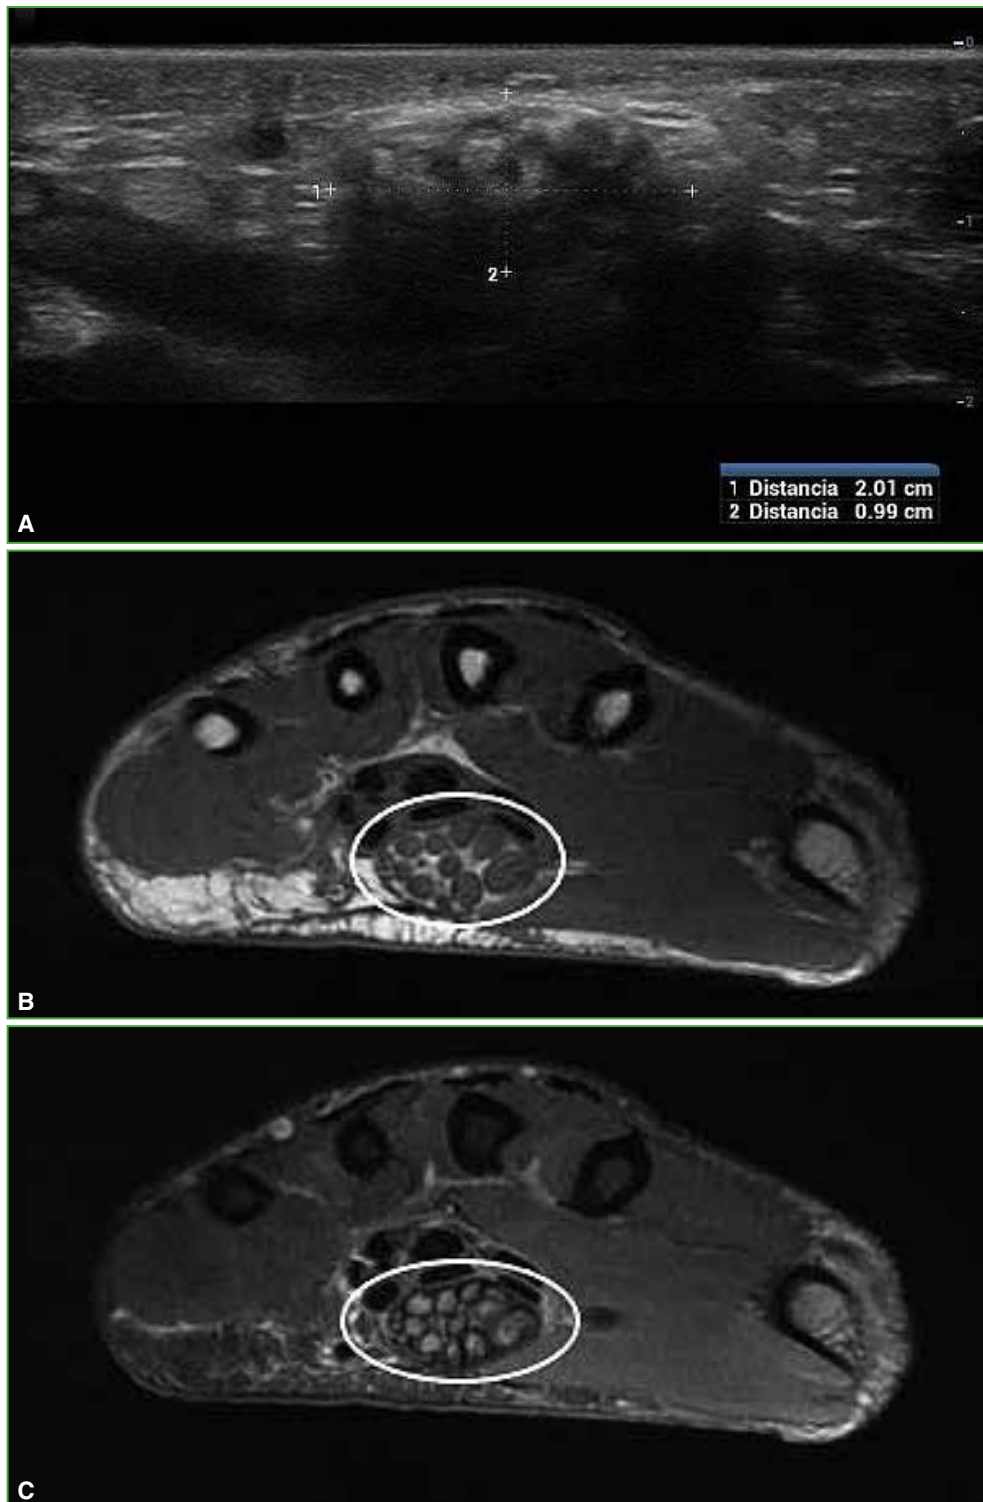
A. Ultrasound of the right wrist with a heterogeneous tumor in the carpal canal. Alternating hypo and hyperechogenic areas. B and C. MRI of the right wrist, axial slice, on T1-weighted and STIR sequences, respectively, showing a marked thickening of the median nerve fibers, which shows hypointensity on T1 sequences and slight hyperintensity on fat suppression sequences, with interspersed linear images which are hyperintense on T1 and hypointense on STIR, compatible with fat. Lipomatous hamartoma of the median nerve.
